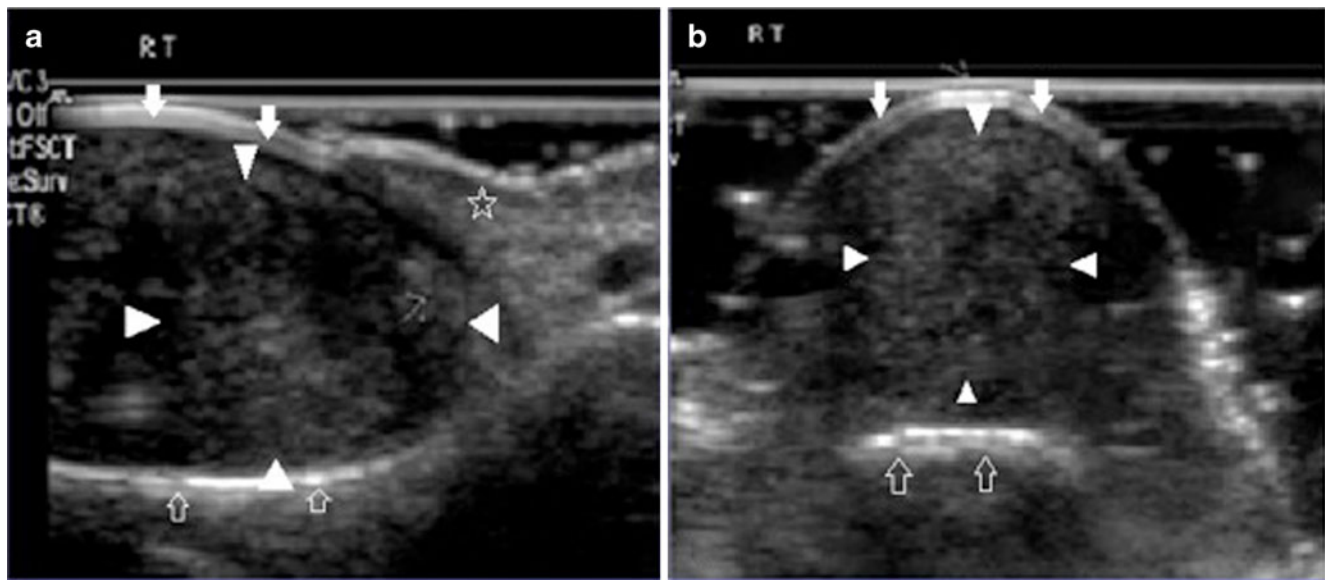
Superficial acral fibromyxoma. a Sagittal ultrasonographic image through the nail complex demonstrating a large, oval lump under the nail plate at the base of the nail near the germinal matrix which is not infiltrated but stretched. The solid well defined mass has an intermediate but uniform echogenicity. b Transverse sonographic
